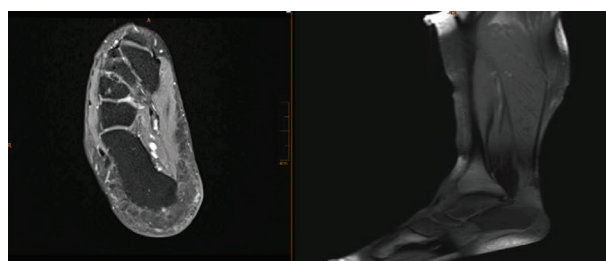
MRI of the right ankle and foot after 24 months of follow-up. A and B views show complete bony union with no signs of instability, avascular necrosis, or talar collapse
